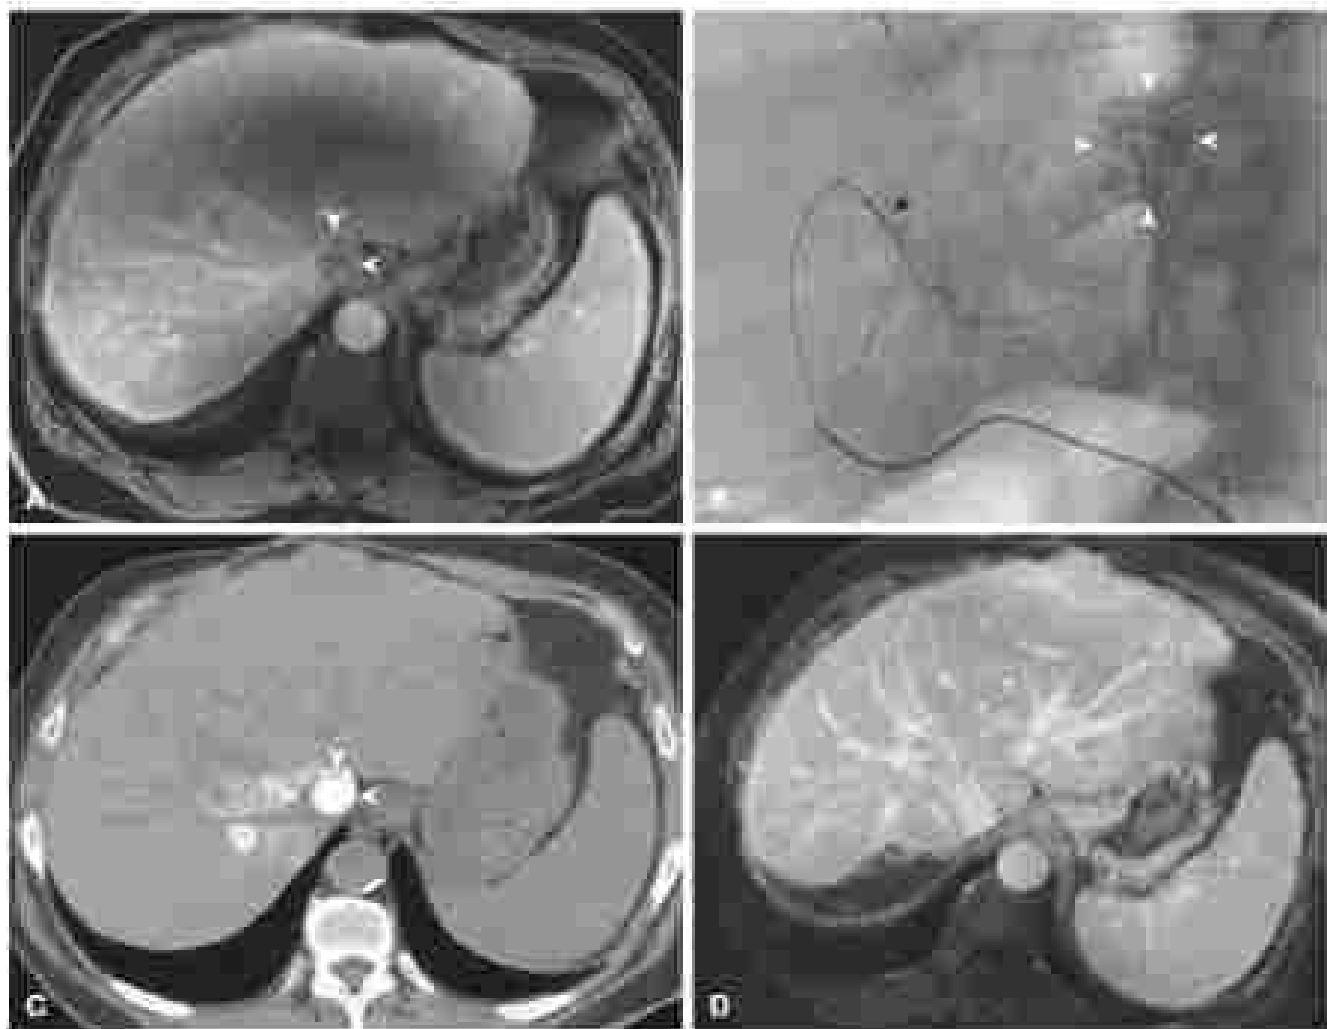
A 64-year-old patient with history of acute rejection for liver transplant. (A) Axial contrast-enhanced magnetic resonance imaging shows a large, lobulated, liver parenchyma-massive, bright and compressing the inferior vena cava. The patient was treated successfully and had no remaining systemic options. (B) Diagnostic angiogram during transarterial chemoembolization shows a subsegmental microvascular pool (arrowhead) and the hypovascular lesion (white arrowheads). (C) Noncontrast CT on posttransarterial chemoembolization shows the dense lipiodol deposition in the targeted lesion (arrowheads). (D) Axial contrast-enhanced magnetic resonance imaging 2 years after treatment shows complete and persistent response with no remaining evidence of disease.
